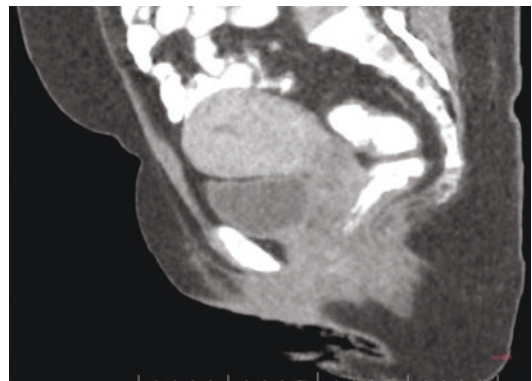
CECT scan (sagittal section) of the same patient of Fig. 12. The mass cannot be clearly delineated. CT lacks contrast between tumour and myometrium
